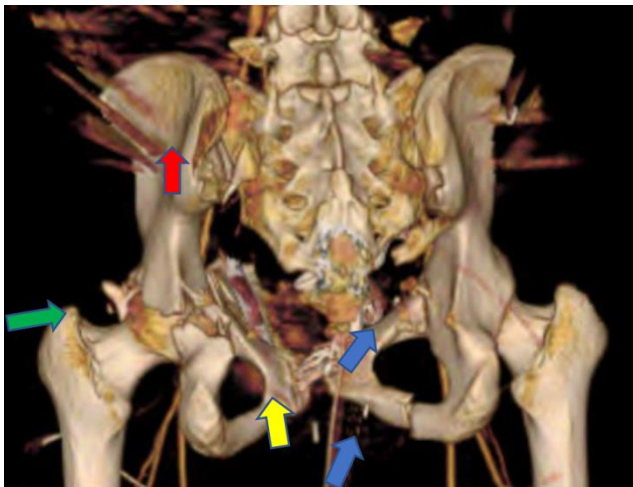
Figure X (Case two): CT pelvis 3-D reconstruction (posterior view) showing the same abnormalities as [Figure IX] and marked by corresponding colored arrows.
